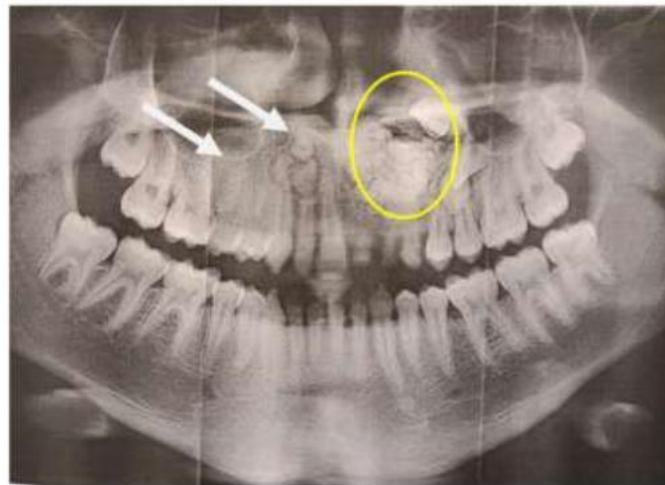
Panoramic radiograph showed
